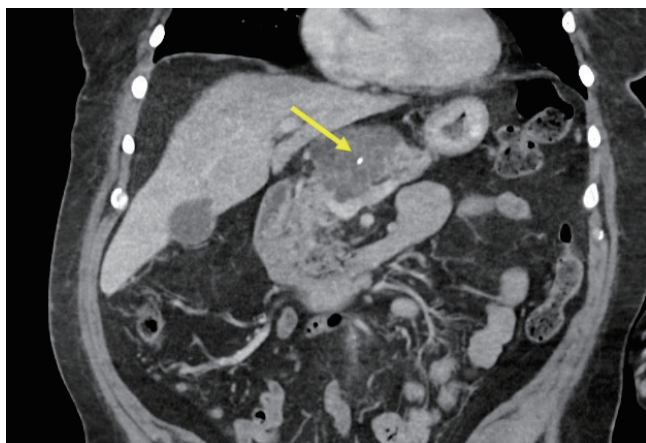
Coronal portal venous phase contrast-enhanced CT scan of a 66-year-old female demonstrates honeycomb appearance and central calcifications (arrow) of a serous cystadenoma measuring 4.2 cm, located in the pancreatic body. Although not necessary based on imaging criteria, the patient underwent endoscopic ultrasound with fine-needle aspiration yielding benign results.
